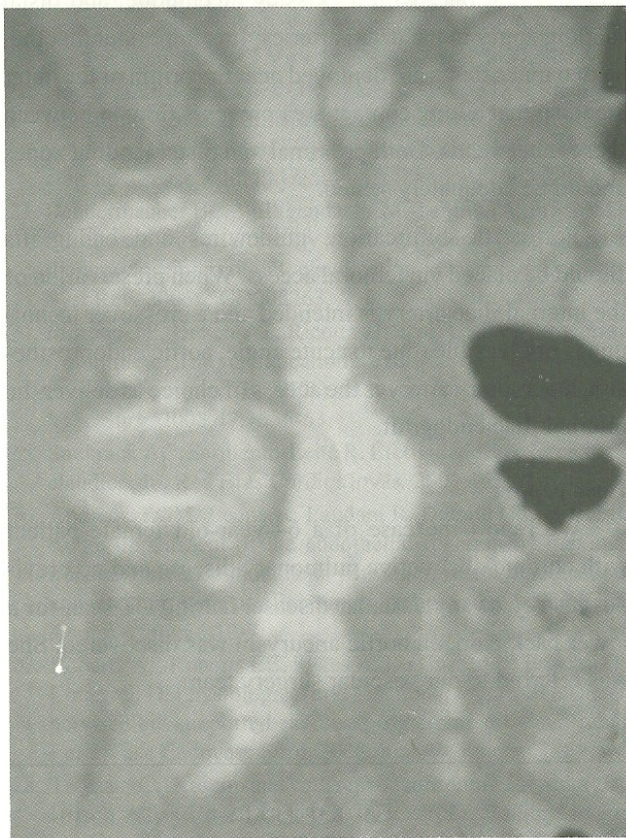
Preoperative computed tomographic angiography: note the aortic ulcer associated with a saccular aneurysm and bifurcation stenosis
